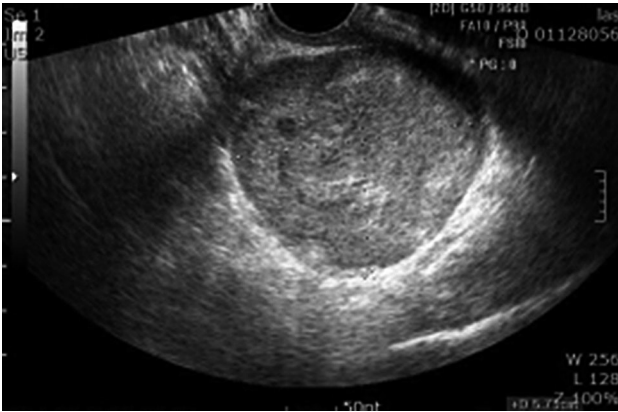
Transvaginal ultrasonography showing a solid mass on the left lower anterior body of the uterus.
